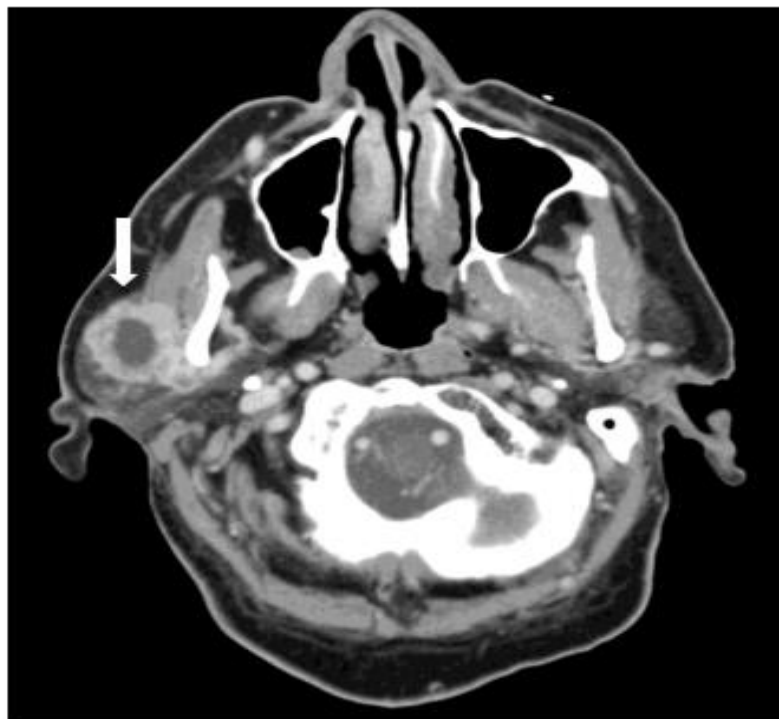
CT scan, axial view - heterogeneous nodule, peripheral contrast enhancement in the right parotid gland, with irregular contours, without a cleavage plane with the right masseter.
